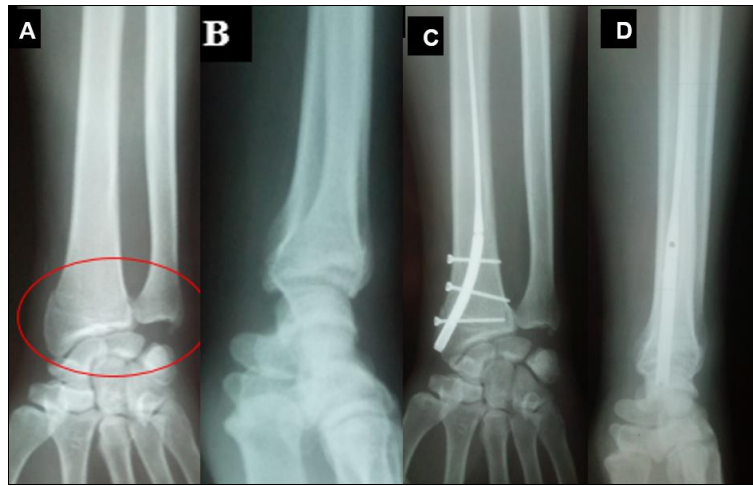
X-ray post-operative control. A + B: showing AP and lateral view of articular distal radius fracture. C+D showing post-operative aspect after nailing
